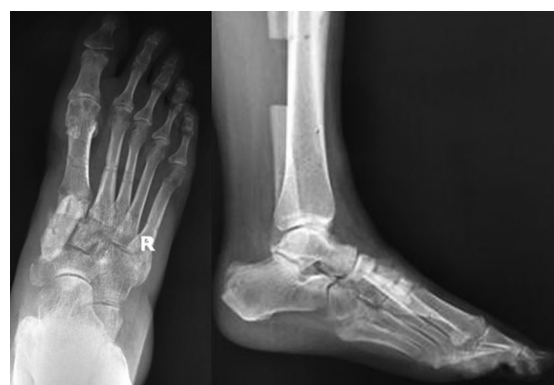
X-ray pictures of the patient's foot in AP and lateral views 90 days after surgery
